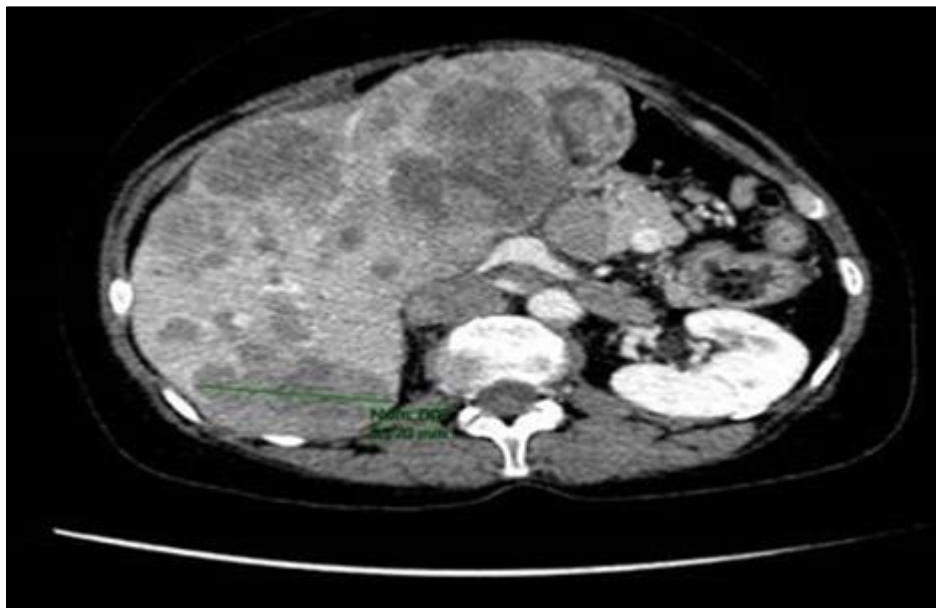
Abdominal CT Scan Showing the Liver Masses in the Segments II, III, IV. The Biggest One Measures 65mm in the Largest Diameter (in Green)
